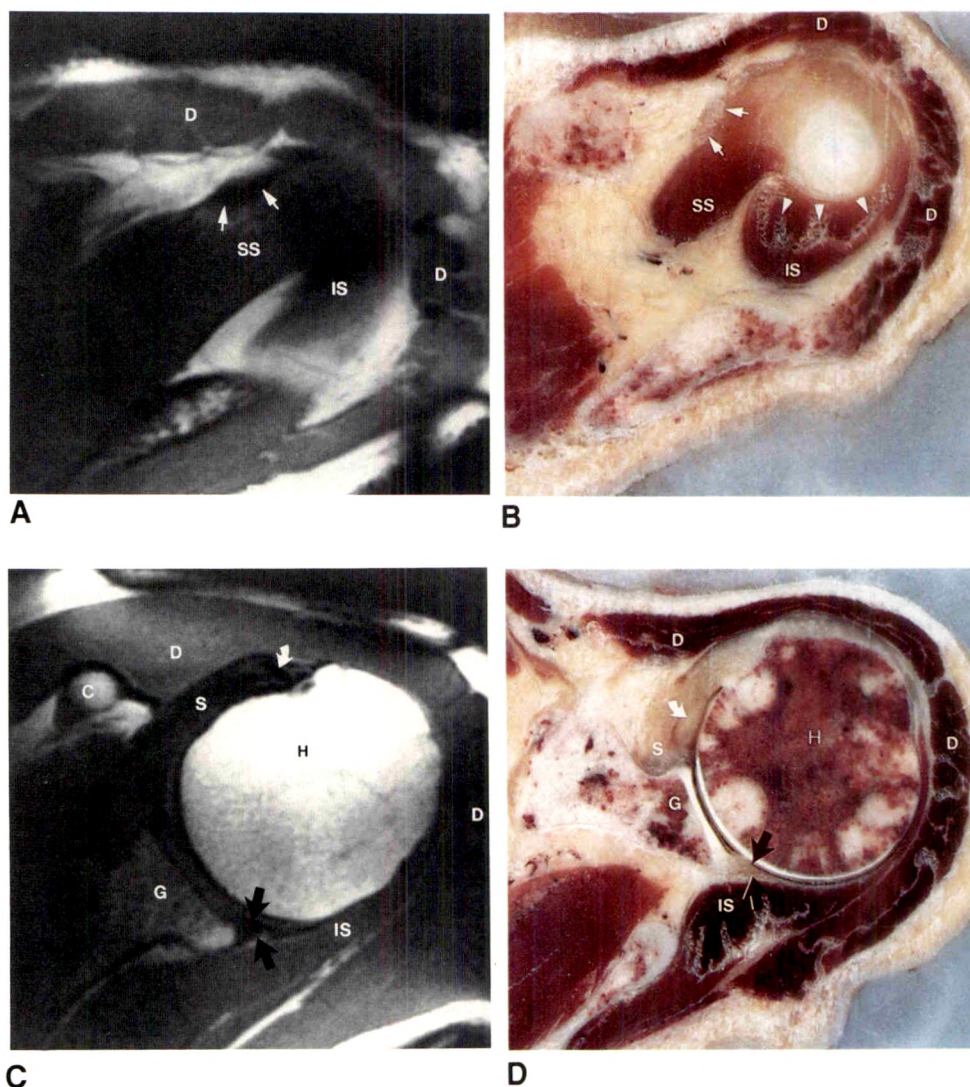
Sagittal MR images (TR = 600, TE = 25) and corresponding anatomic sections through the medial (A, B), middle (C, D), and lateral (E, F) humeral head. See Key to Abbreviations on page 560.
